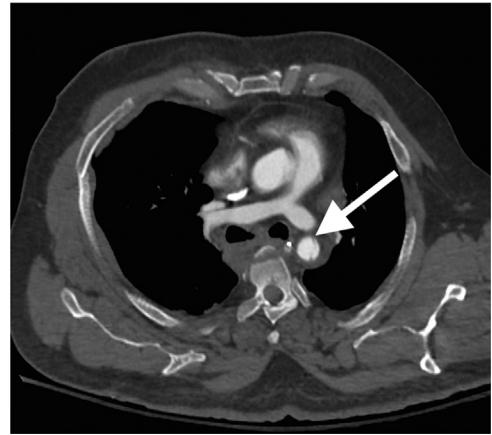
CT angiography of a high-speed motor vehicle collision patient shows a dissection involving the aortic arch (arrow). The patient had no regional atherosclerotic disease. This patient also has sternal and spine fractures (shown in Figure 18).
